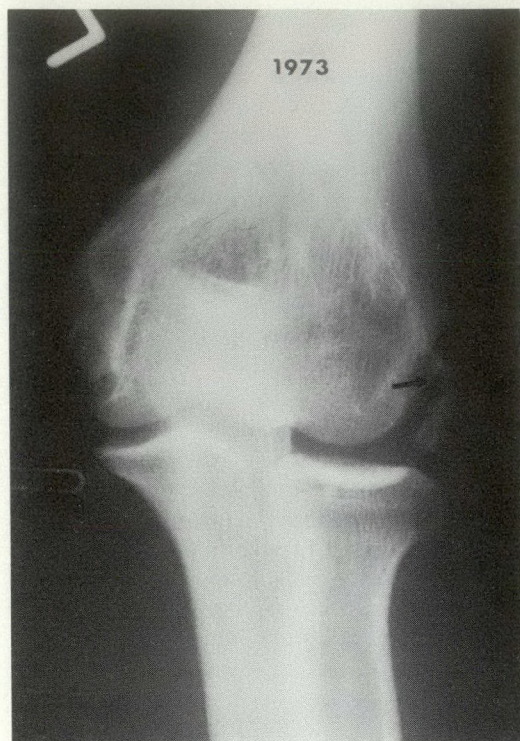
Long-term follow-up radiograph of fracture associated with dislocation of elbow showing lateral periosteal calcification.
